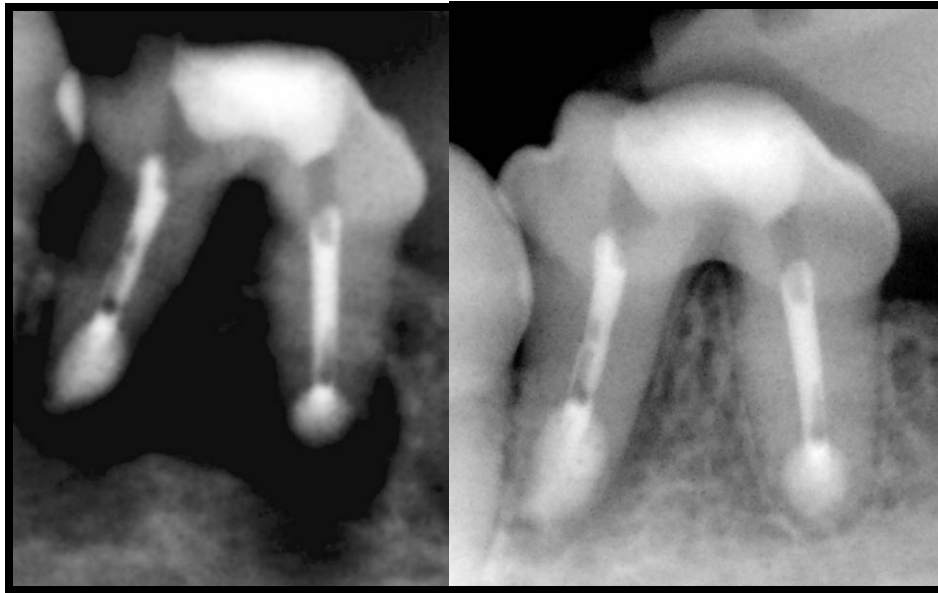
“Geristore tooth” radiographs post-surgical vs. 6 month follow-up 2
